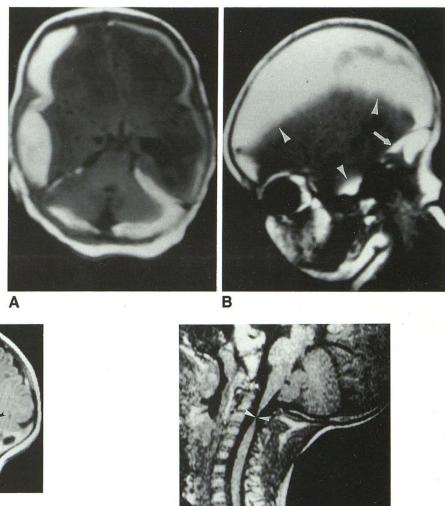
Birth trauma; tentorial bleeding from dural venous sinuses fills the quadrigeminal plate cistern, compressing the cerebellum. Sagittal T1-weighted MR shows high signal intensity methemoglobin (*arrowheads*) outlining the quadrigeminal plate cistern and superior cerebellar cistern, compressing the anterior superior vermis and quadrigeminal plate. Bleeding arose from dural sinuses in the tentorium.
